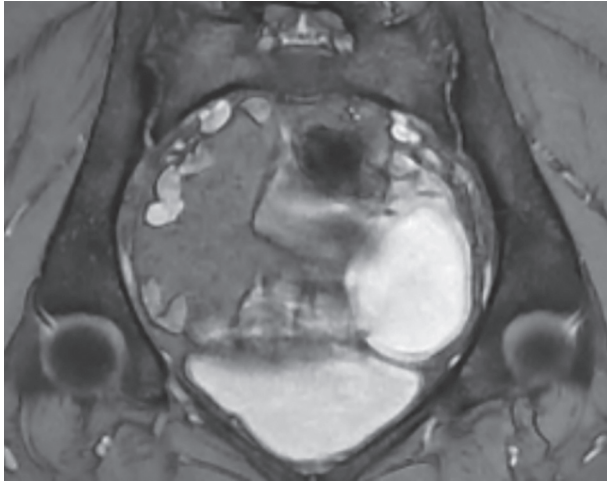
An MRI image of the cystic lesion in the left ovary
